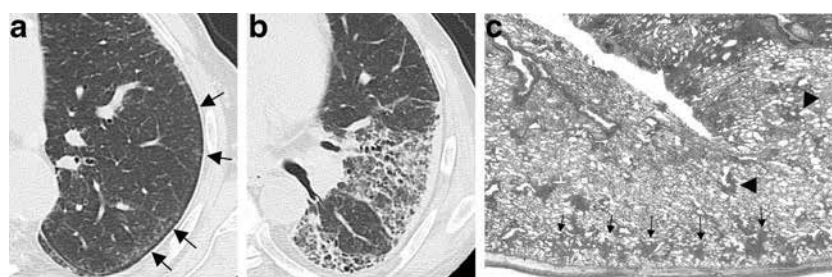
A 76-year-old previous asbestos insulation male worker with asbestosis. a. HRCT of left upper lobe shows a typical subpleural curvilinear line. Note that the line is formed by the coalescence of dot-like opacities and is identified along the lateral chest wall as well as in the dependent lung. b. HRCT of the left lower lobe shows ground-glass opacity with fine reticulation and strong traction bronchiectasis in segmental distribution, precluding the diagnosis of idiopathic
